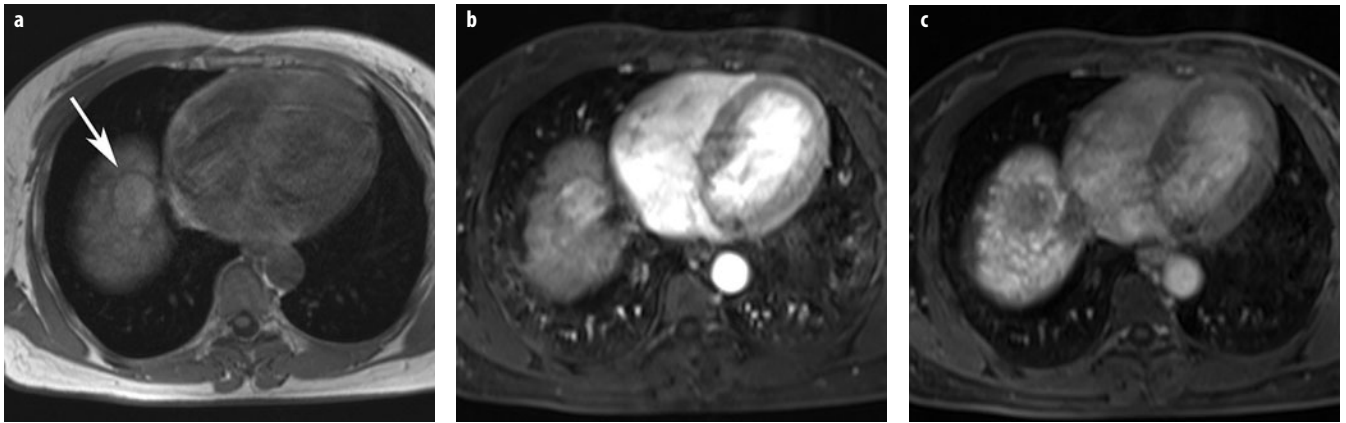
a-c. HCC MRI with liver-specific agent (gadoteric acid). a Axial T1-weighted GRE image shows an encapsulated, slightly hyperintense, mass in the dome of the liver (*arrow*). b Gadoteric-acid-enhanced image shows strong enhancement in the arterial phase. c In the hepatobiliary phase, after 20 min, the lesion shows hypointensity due to lack of hepatocellular uptake
